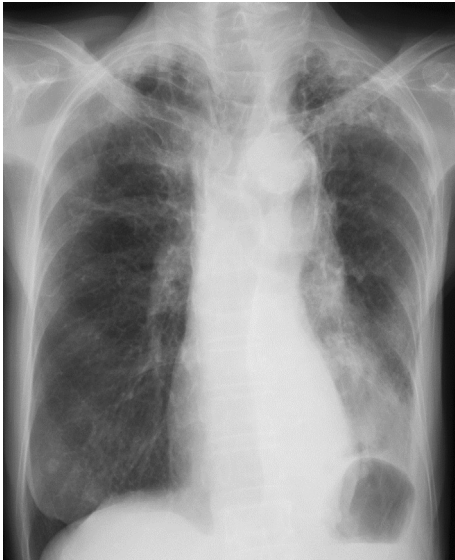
Chest radiograph on the first visit shows left lower lobe collapse.
